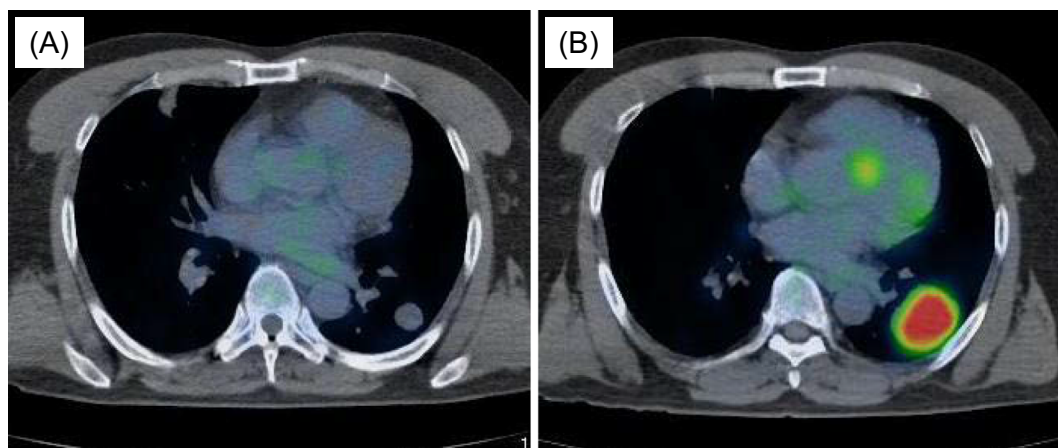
PET-CT findings. (A) A slight increase of FDG uptake (SUV: 1.4) was observed in the nodule in the left lower lobe. (B) The SUV-max (7.6) of the nodule in the left lower lobe was further elevated during the follow-up period.
